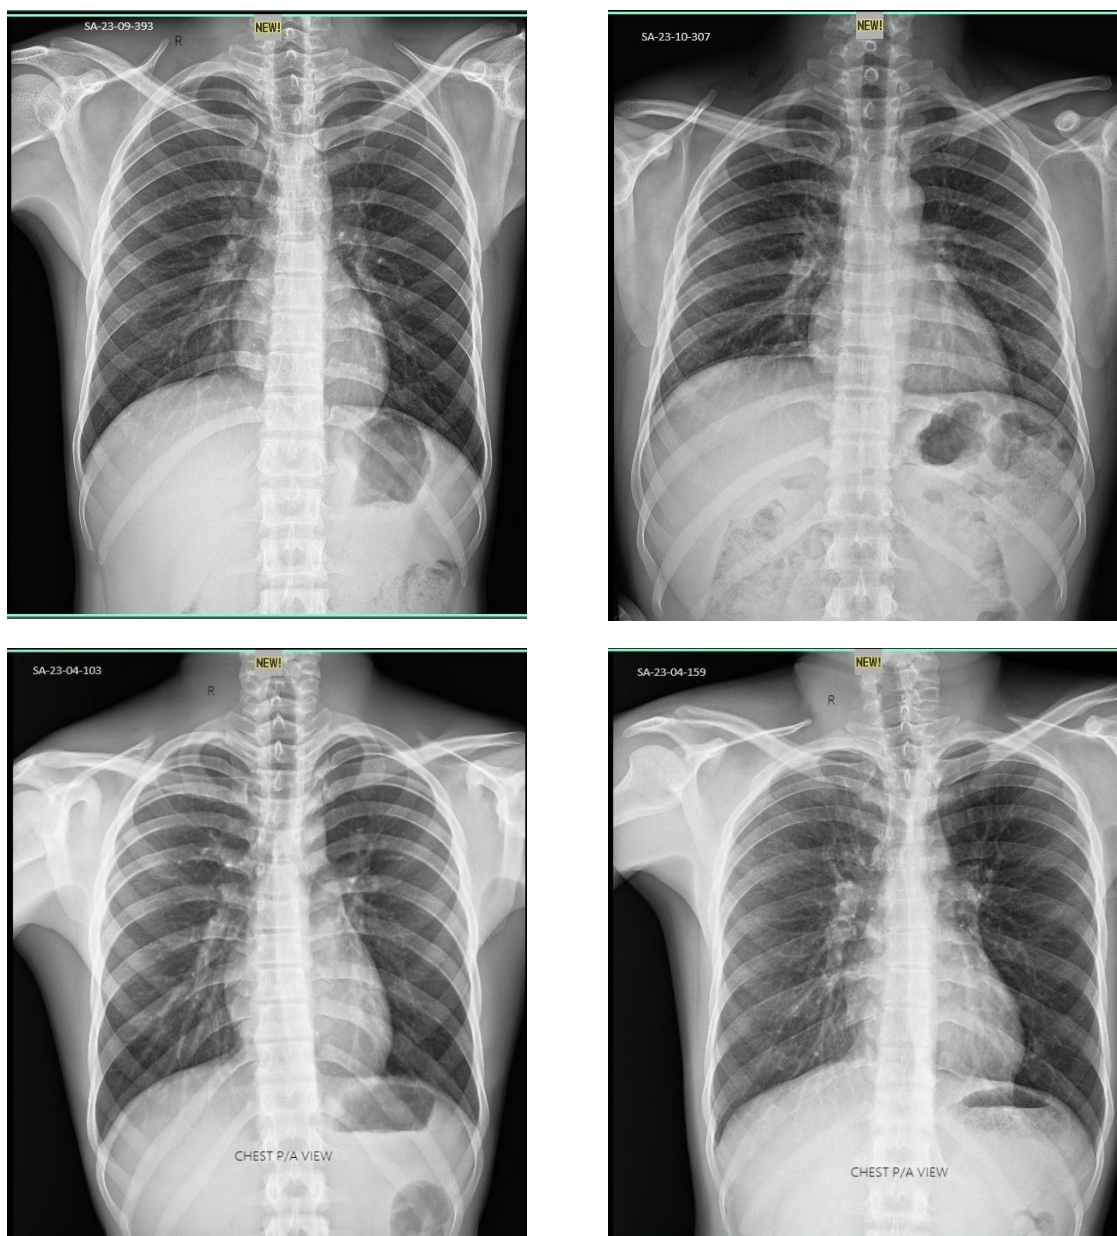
Chest P/A view X-Ray report of HBsAg positive patients
